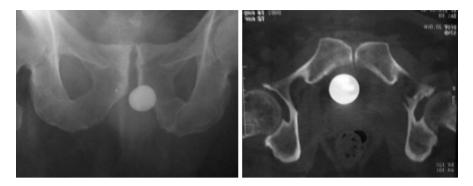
Deflate of the balloon, radioscopic (right) and CT (left) view [8]
